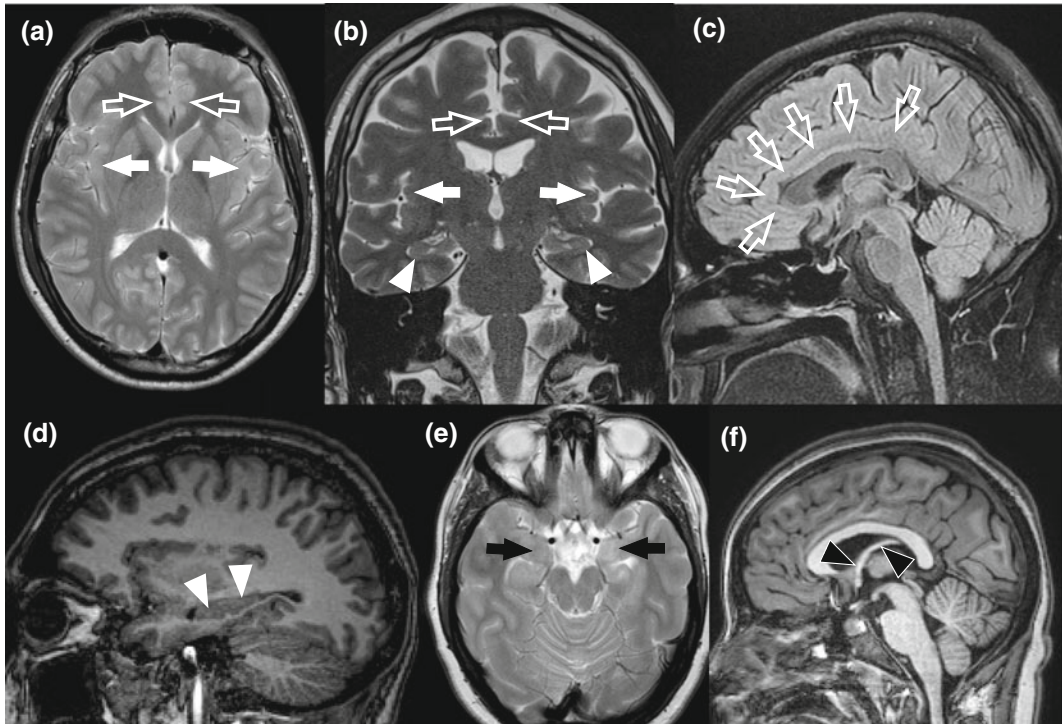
Limbic system. Axial T2 (a, e), coronal T2 (b), sagittal FLAIR (c) and sagittal T1 volume (d, f). The insular cortex is shown by the *closed white arrows*; the cingulate cortex (*open white arrows*) wraps around the corpus callosum in the midline. The hippocampus is demonstrated in the medial temporal lobes (*white*
